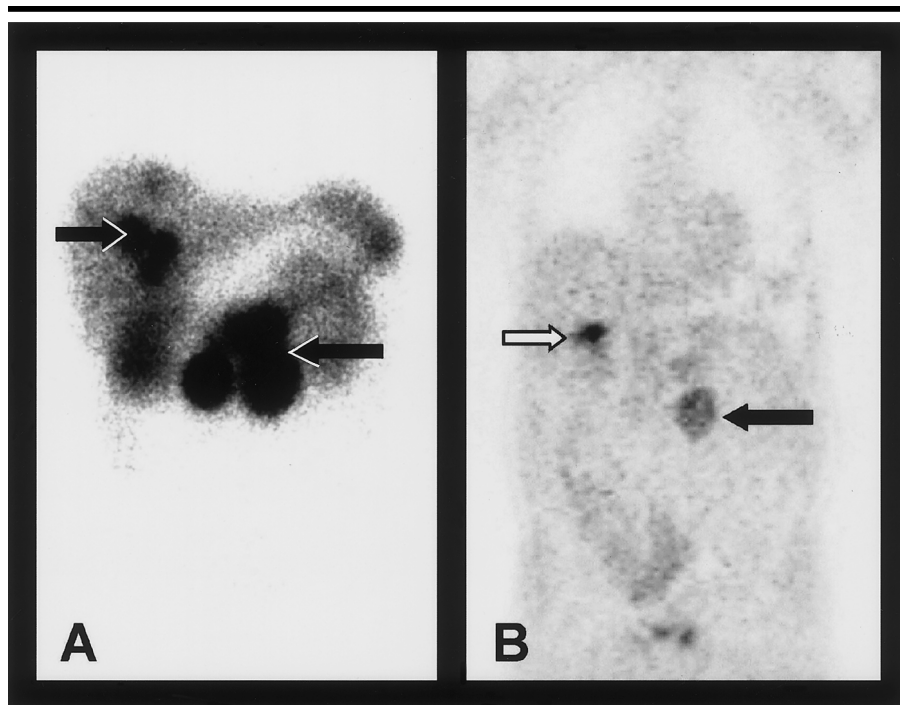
Metastases of an unknown primary tumor in a 59-year-old man. Coronal somatostatin-receptor scintigram (A) and CT scan (not shown) both revealed all known tumors—multiple serotonin-negative lymph node metastases (long black arrow) and multiple hepatic metastases (short black arrow)—whereas the coronal ^{18}F dopa PET image (B) showed only moderate ^{18}F dopa accumulation in one of the lymph node metastases (black arrow) and normal uptake in the gallbladder (white arrow).
